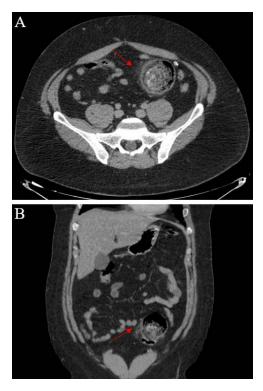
Computed tomography. Large diverticular image with fecal content inside, thickened wall and surrounding peripheral inflammatory changes are shown (arrows).
